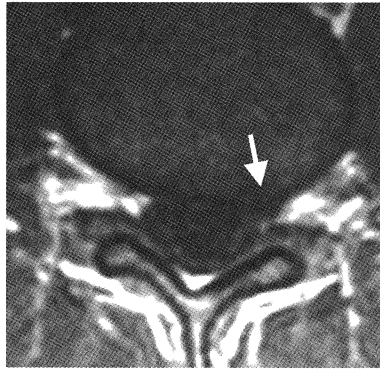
Axial T1-weighted magnetic resonance image (MRI) through the L4-L5 disc showing the left posterolateral disc herniation (arrow).
